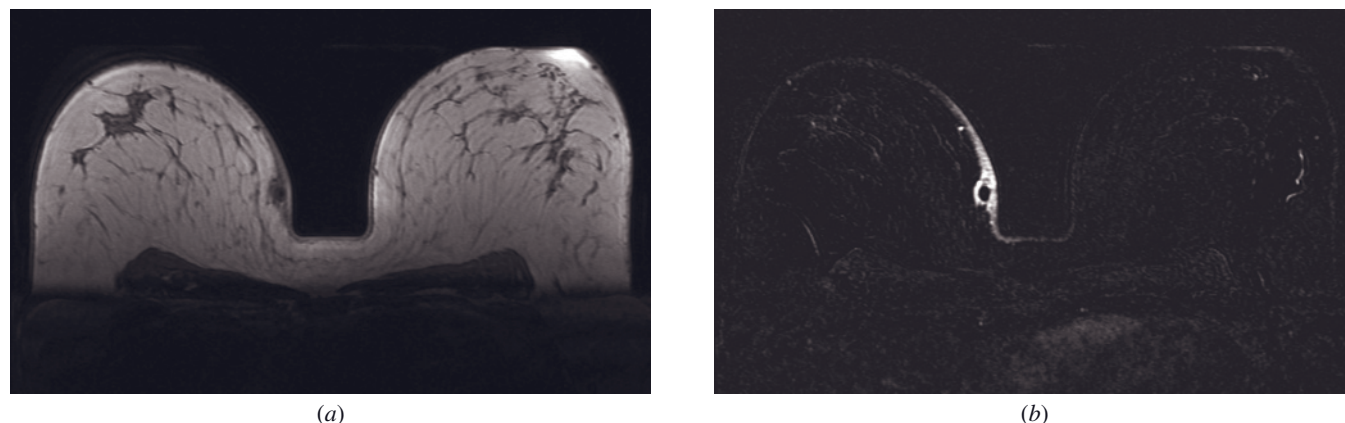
Abscess. Axial T2-weighted image (a) reveals an oval, well-circumscribed subcutaneous mass, surrounded by perifocal inflammatory changes and skin thickening, located in the medial aspect of the right breast. Strong ringlike and skin enhancement is seen on the axial postcontrast subtracted image (b).
